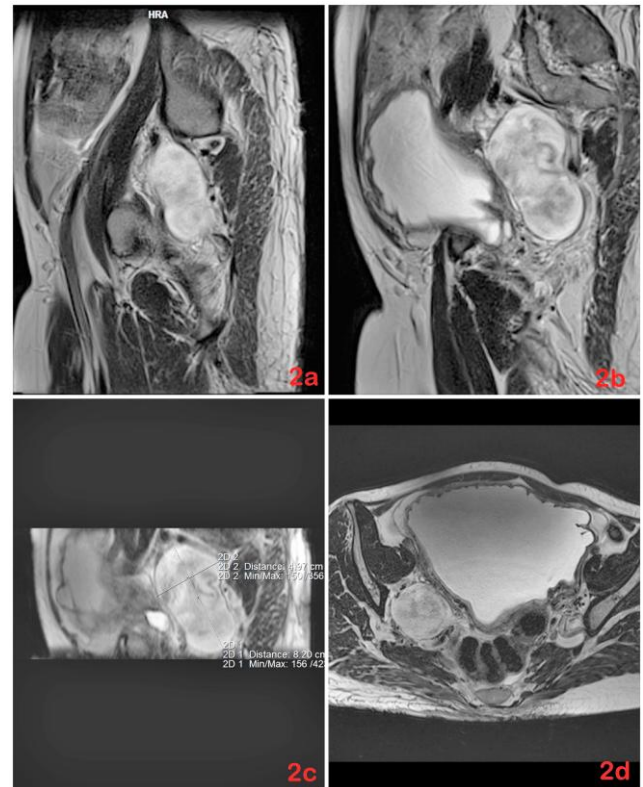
A), B), and C) An MRI images of abdomen, small pelvis, gluteal area and thighs with data for a 9cm mass with irregular shape, lying on the right side of the pelvis and a conclusion about giant pelvic neurofibroma; D) MRI of a small pelvis showing an enlarged, hypotonic bladder with multiple diverticulitis
